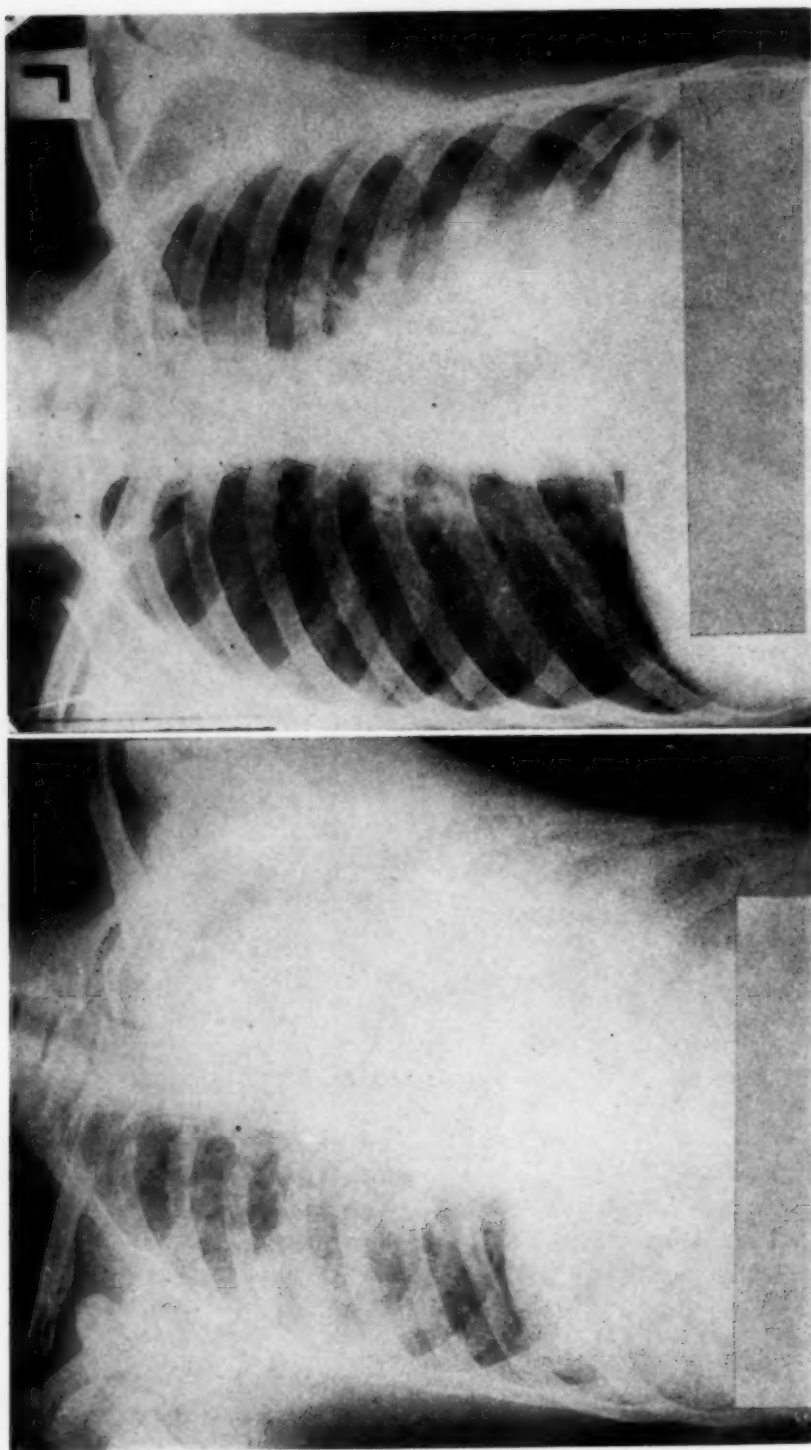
Roentgenograms of case 13 (left, April 17, 1945; right, May 15, 1945). Onset of streptococcus bronchopneumonia and empyema on the left on April 16, 1945. The shadow on the left side in the roentgenogram of May 15, 1945 represents pleural thickening only.
